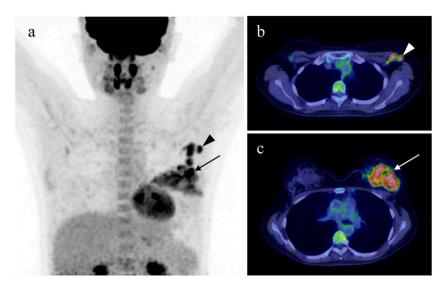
18F-FDG PET/CT delayed image (120 min) in the prone position (2 days after the administration of cabergoline). (a): 3D-MIP. (b, c): axial fusion images. Background breast fibroglandular uptake was mild (SUVmax = 1.3). Enlarged level I axillary lymph nodes showed increased 18-F FDG uptake (SUVmax = 7.7) (arrowheads). The upper left mammary gland showed segmental 18-F FDG uptake (SUVmax = 8.0) (arrows).
